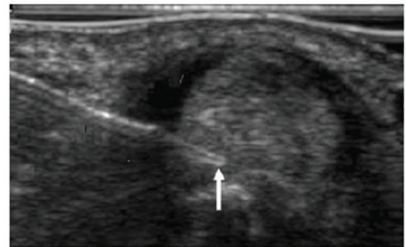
Ultrasound image, at the time of delivery of injection into the 1st extensor compartment
